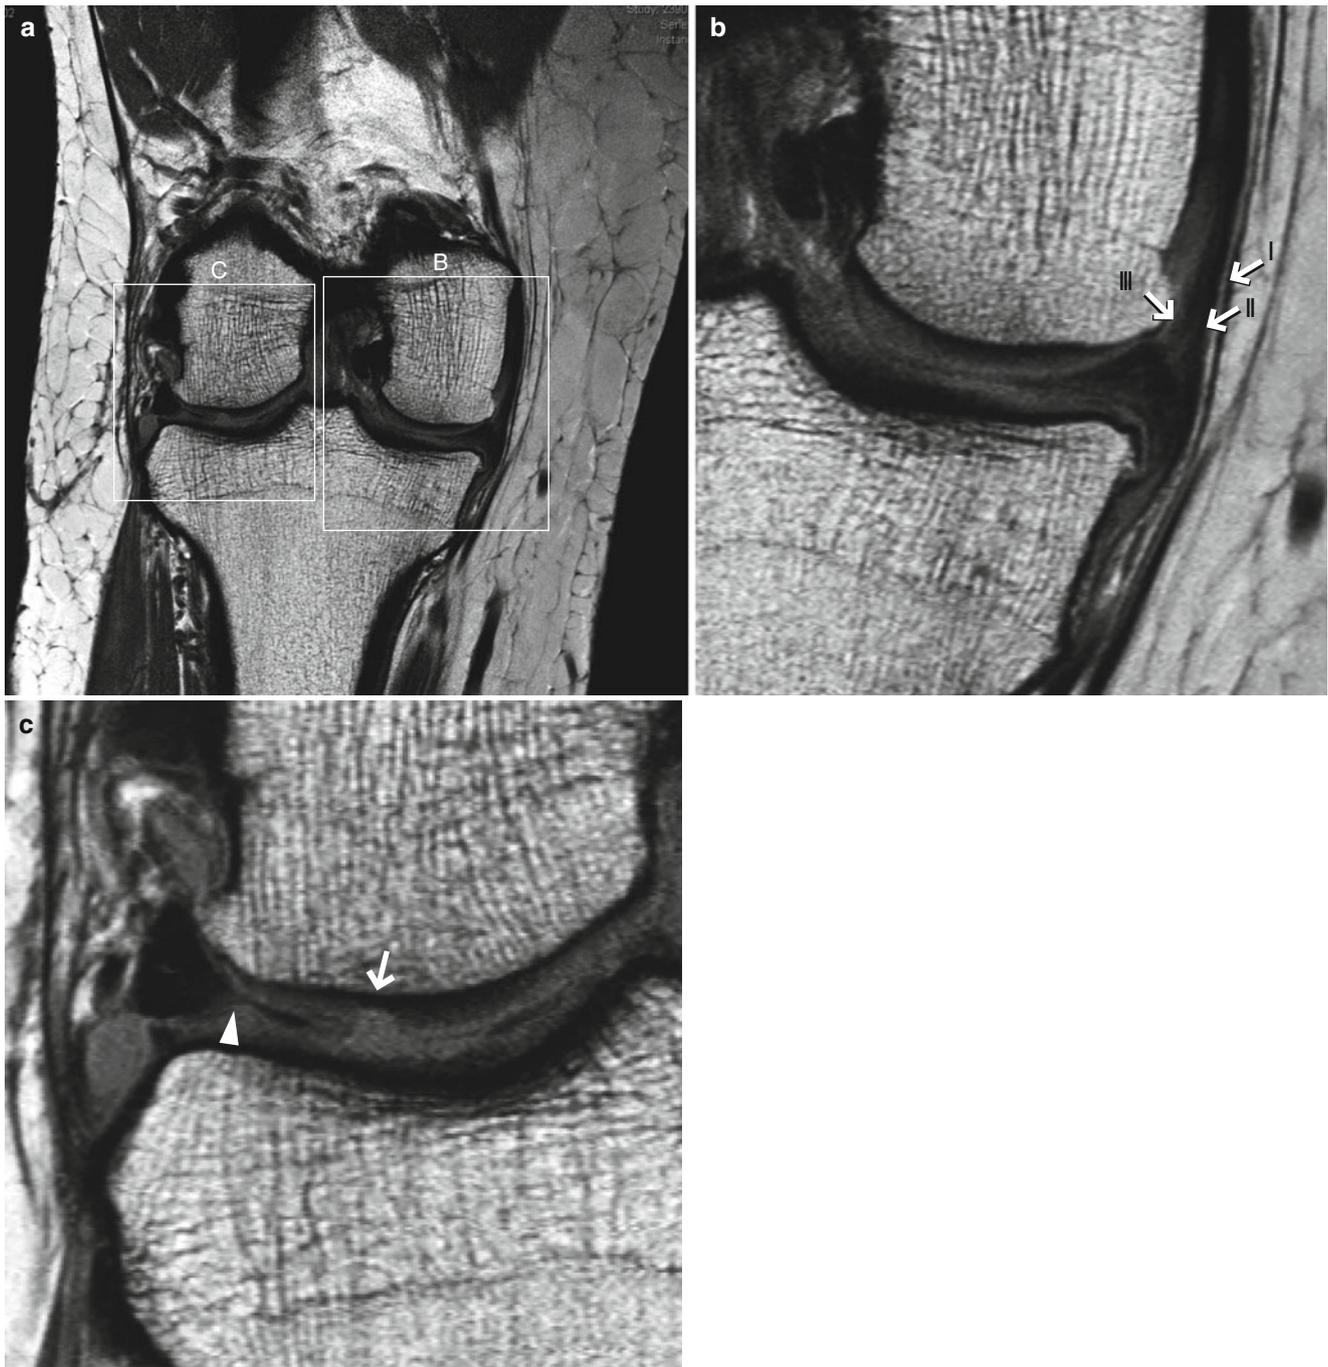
3.0 T MRI of the knee. Coronal image (a) and the magnified images (b and c). (a) FSE 2,025/20, 3.0/0.3, FOV 160, matrix 1024×1024. (b) Magnified image of the medial compartment shows three layers of the medial collateral ligament (I, II, III, *arrows*). The quality of image is equivalent to that offered by high-resolution images
